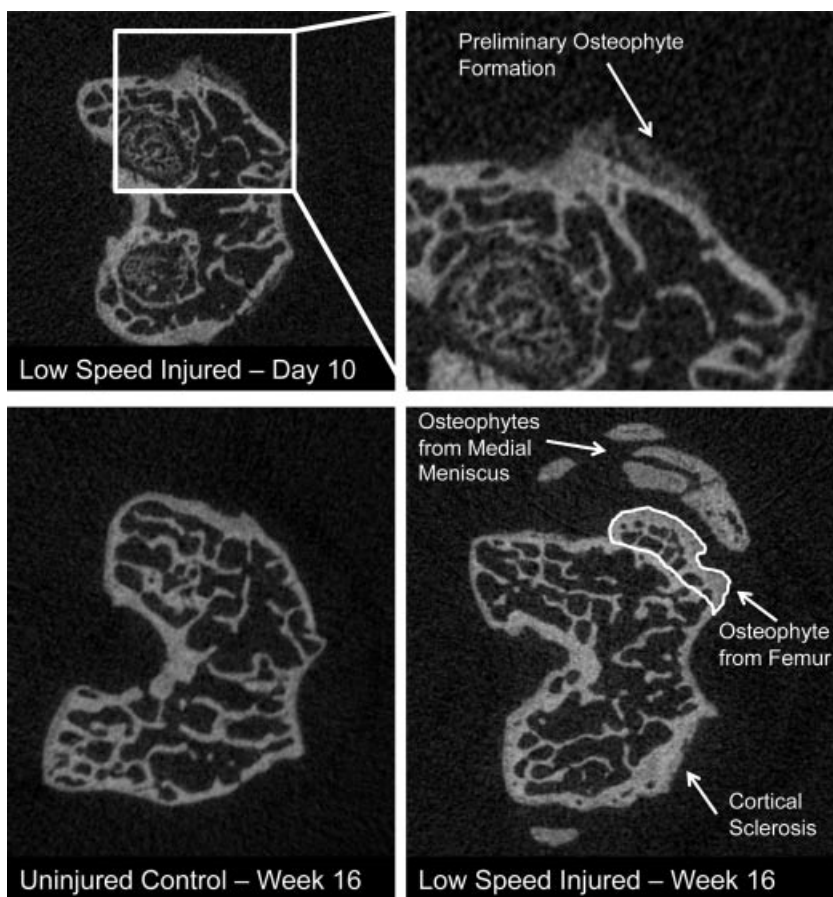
Transverse μ CT slices of the distal femur. Top: Femoral epiphysis of an injured joint 10 days postinjury, with expanded image showing early osteophytosis from the anteromedial femur. Bottom: Uninjured (left) and injured (right) femoral epiphysis at 16 weeks showing considerable osteophyte formation from the anteromedial femur and medial meniscus, as well as sclerosis of cortical plate on the lateral condyle.
